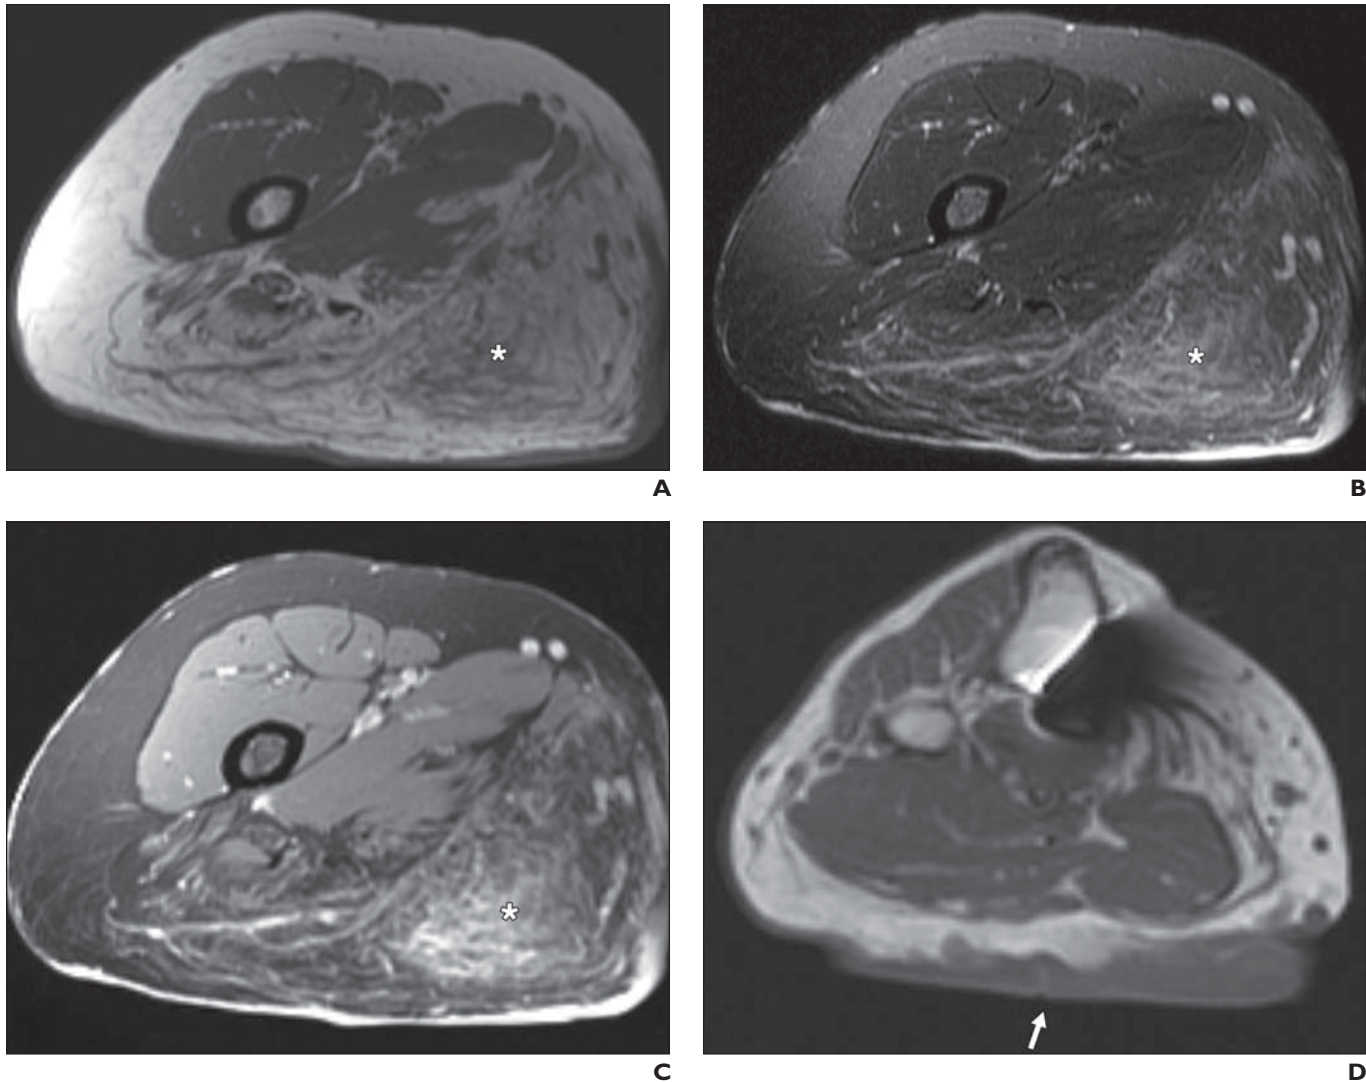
47-year-old woman with neurofibromatosis type 1. A, Transverse T1-weighted MR image of thigh shows infiltrative mass in posteromedial subcutaneous fat (*asterisk*) representing diffuse neurofibroma. B, Transverse fat-suppressed T2-weighted MR image shows reticulated high signal intensity of mass (*asterisk*). C, Transverse fat-suppressed T1-weighted MR image obtained after IV administration of gadolinium chelate shows enhancement of diffuse neurofibroma (*asterisk*). D, Transverse T1-weighted MR image of upper calf shows plaquelike thickening of skin posteriorly (*arrow*) representing another diffuse neurofibroma.
